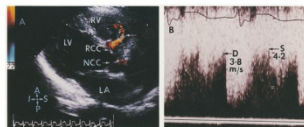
Parasternal long-axis view with color flow imaging (A) showing a ruptured right aortic sinus of Valsalva and communication with the right ventricle and left-to-right shunt flow signal (arrow). Continuous wave Doppler interrogation of the shunt flow (B) shows a high-velocity systolic (S) signal of 4.2 and a high-velocity diastolic (D) signal of 3.8 m/sec due to continuous pressure gradient between the aorta and the right ventricle. A, Anterior; L, inferior; LA, left atrium; LV, left ventricle; LVCC, noncoronary aortic valve cusp; P, posterior; RVCC, right coronary cusp; RV, right ventricle; S, superior.
